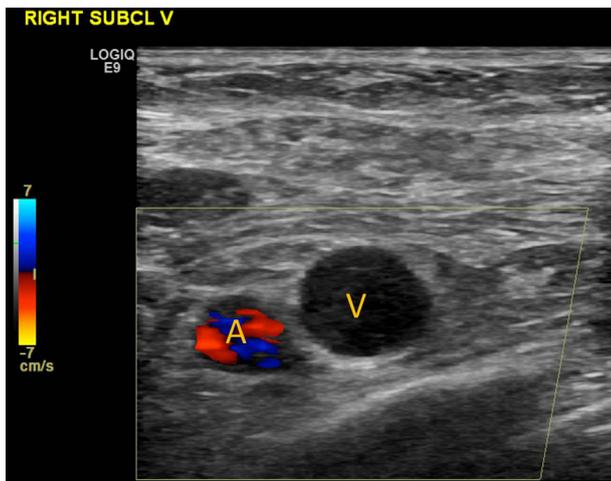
Color US-Doppler image of the right subclavian artery (A) and vein (V). Note the normal flow in the artery while no blood flow was detected in the vein.
